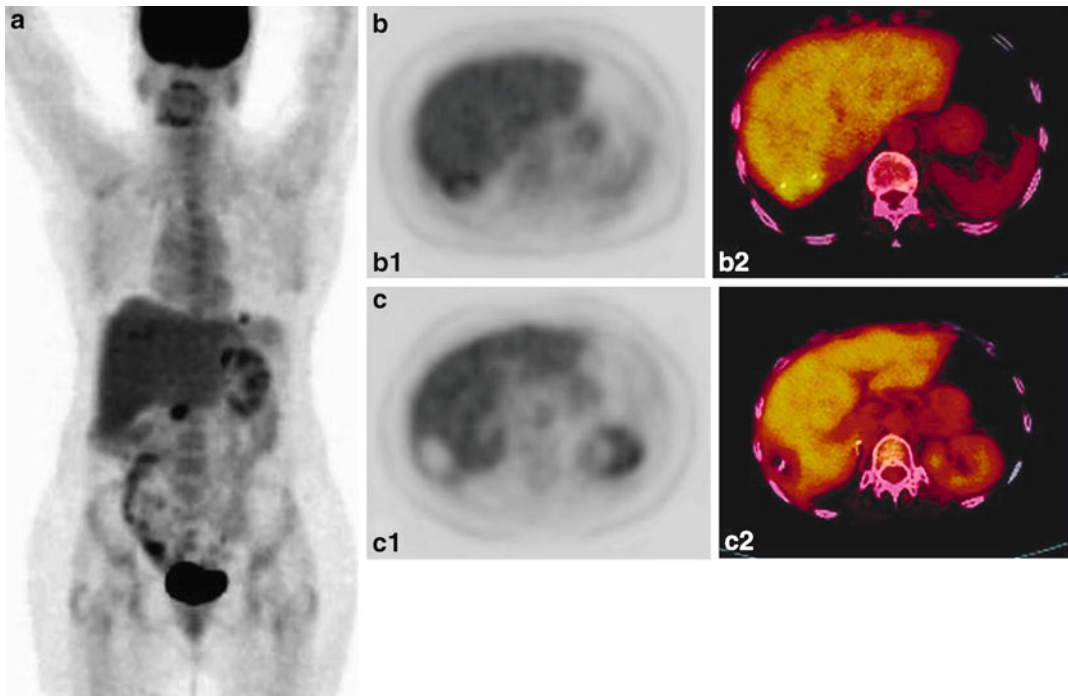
Patient with colorectal cancer, liver metastases treated by RF, and abdominal lymphadenopathy. Evaluation of RF ablation efficacy by [^{18}F]FDG-PET. (a) MIP image, (b1) axial PET image showing physiological aspect of liver metastases after radiofrequency ablation (homogeneous and peripheral mild [^{18}F]FDG uptake), (b2) axial
